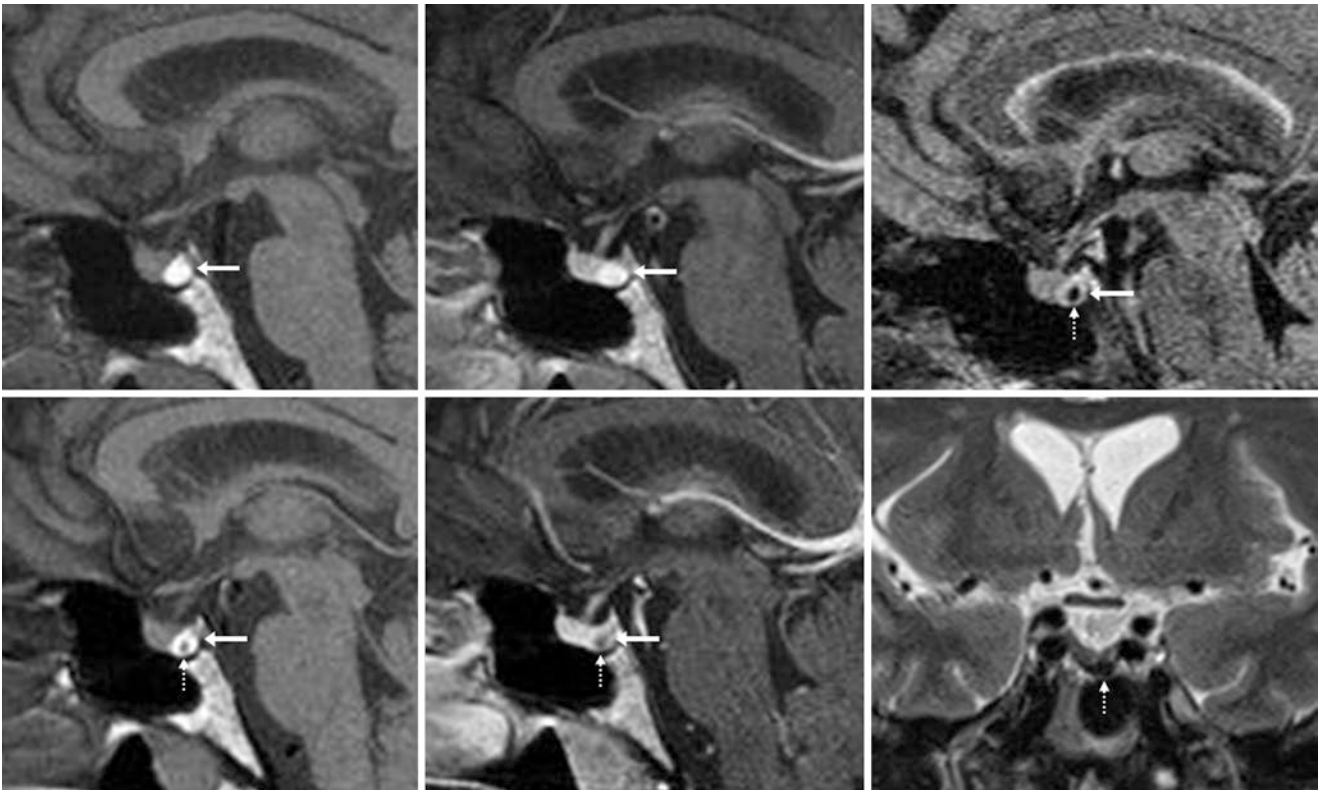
The patient was a 43-year-old female with symptoms of stroke (negative pituitary serum tests). A 1.5 T MRI showed a 7-mm RCC (arrows) just posterior to the anterior lobe that was hyperintense on sagittal precontrast (top left) and postcontrast (top middle) T1WIs. On sagittal FLAIR (top right), a T2-dark focus (dotted arrows) was thought to be hemorrhage within the RCC. On an MRI 1.5 years later, precontrast (bottom left) and postcontrast (bottom middle) sagittal T1WIs demonstrated the hemorrhage within the RCC, which continues to be dark on coronal T2WI (bottom right)
